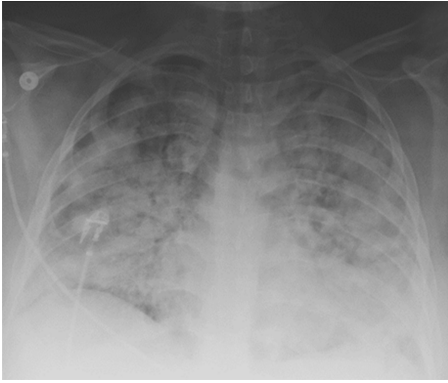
Patient's anterior-posterior chest X-ray film prior to intubation.
